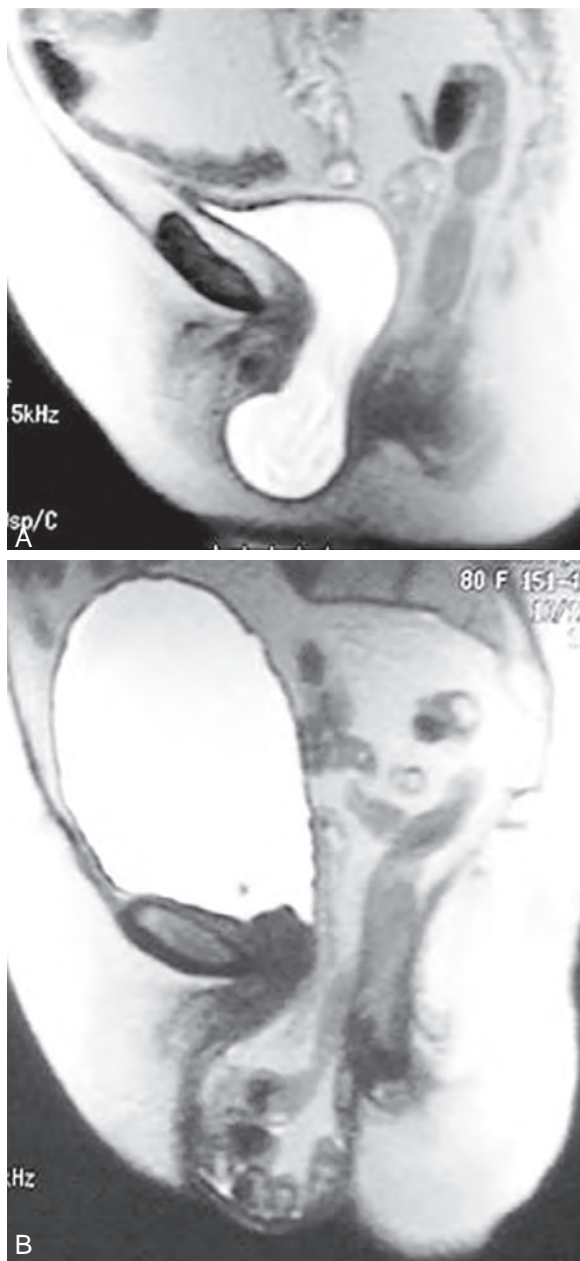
A, Magnetic resonance image (MRI) of female pelvis with isolated cystocele defect. B, MRI of female pelvis with isolated enterocele defect. (From De Almeida FG, Rodriguez LV, Raz S. Magnetic resonance imaging in the diagnosis of pelvic floor disorders. *Int Braz J Urol* 2002;28:553–9.)
